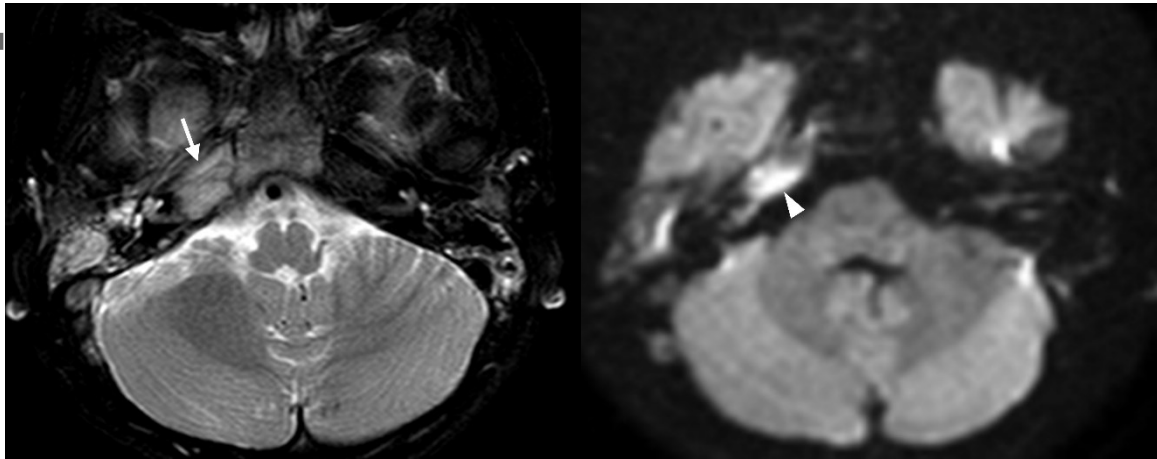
6-year-old female with right petrous apicitis. Fat-suppressed T2-weighted image (A) shows high signal intensity in the right petrous apex (arrow), consistent with petrous apicitis. Diffusion-weighted imaging (B) shows localized high signal intensity in the right petrous apex (arrowhead), indicating the presence of an abscess.
